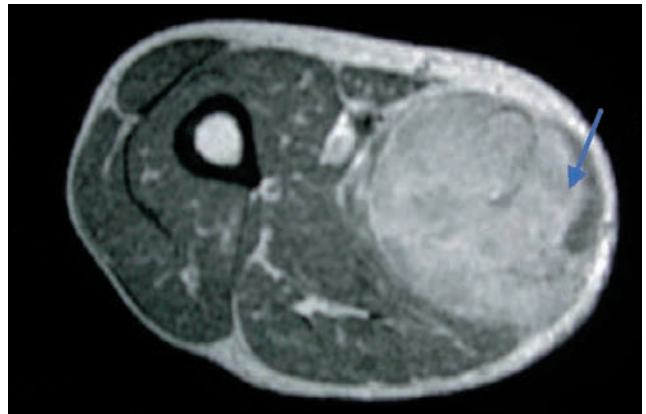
The magnetic resonance imaging (MRI) image shows a well-defined soft-tissue mass, deep to the fascia and larger than 5 cm, with signal characteristics that are not suggestive of a benign fat, neurogenic, or vascular tumor. The MRI characteristics suggest a sarcoma. The arrow indicates the most appropriate path for biopsy, avoiding the neurovascular bundle and not cross-contaminating compartments. In this case, a core biopsy revealed a high-grade soft-tissue sarcoma.
